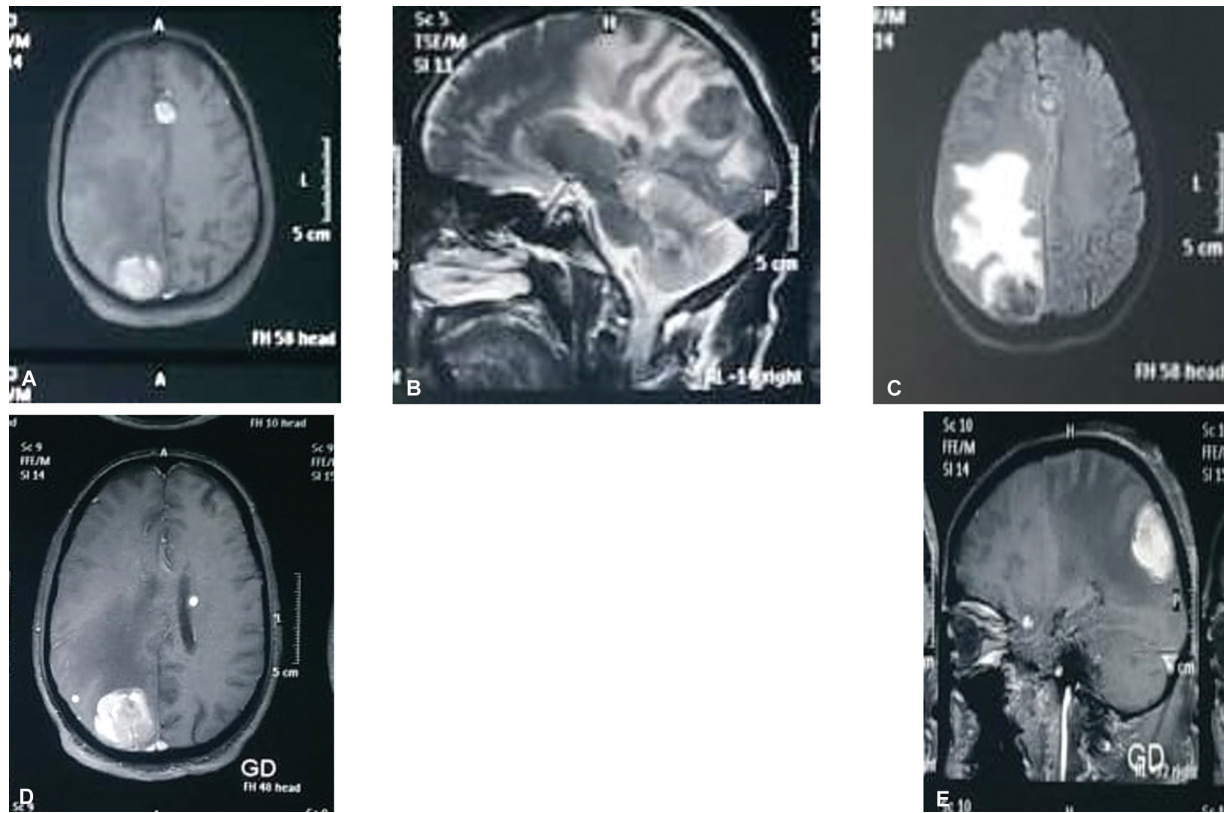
Magnetic resonance imaging (MRI) of the brain. (A) T1W axial, (B) T2W sagittal, (C) axial fluid attenuated inversion recovery (FLAIR), (D) axial contrast-enhanced MRI, and (E) sagittal view.
